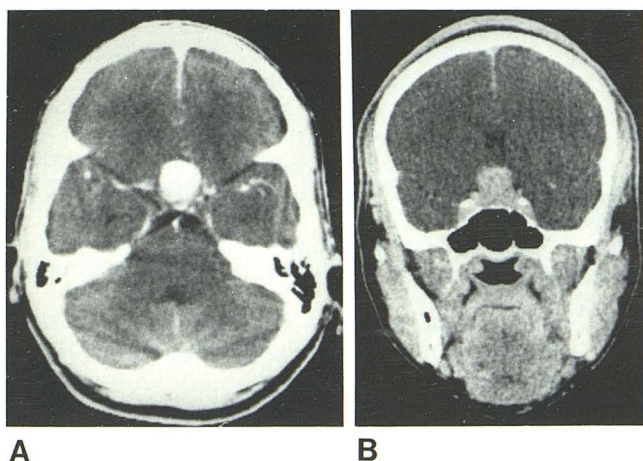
Axial (A) and coronal (B) CT sections after infusion of 300 ml of diatrizoate meglumine. Large enhancing mass in sella and suprasellar region.
